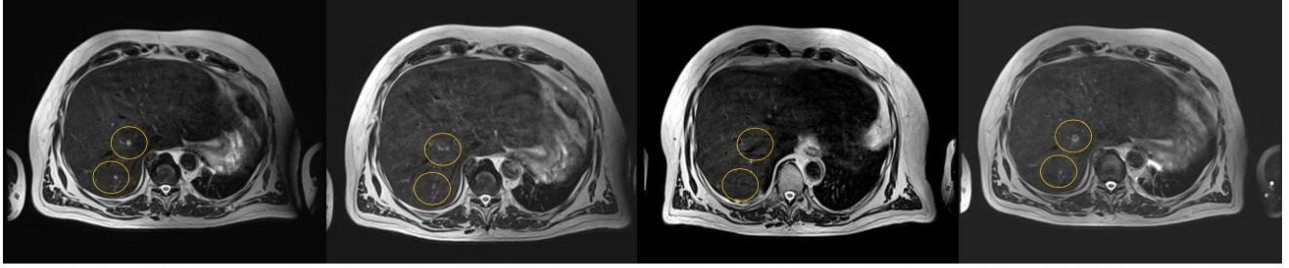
MRI April 2017, T2w sequence
